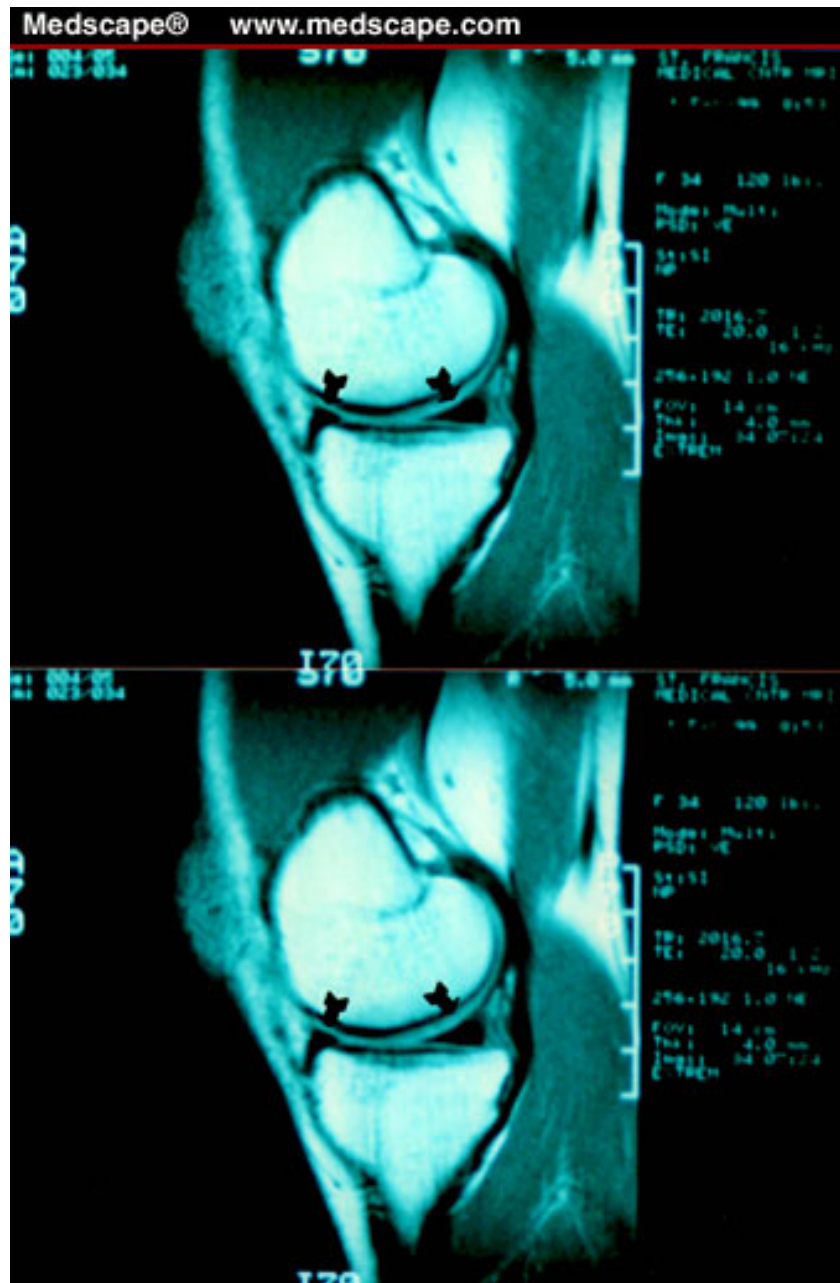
Normal MR imaging of the knee demonstrating intact medial meniscus (arrows).
